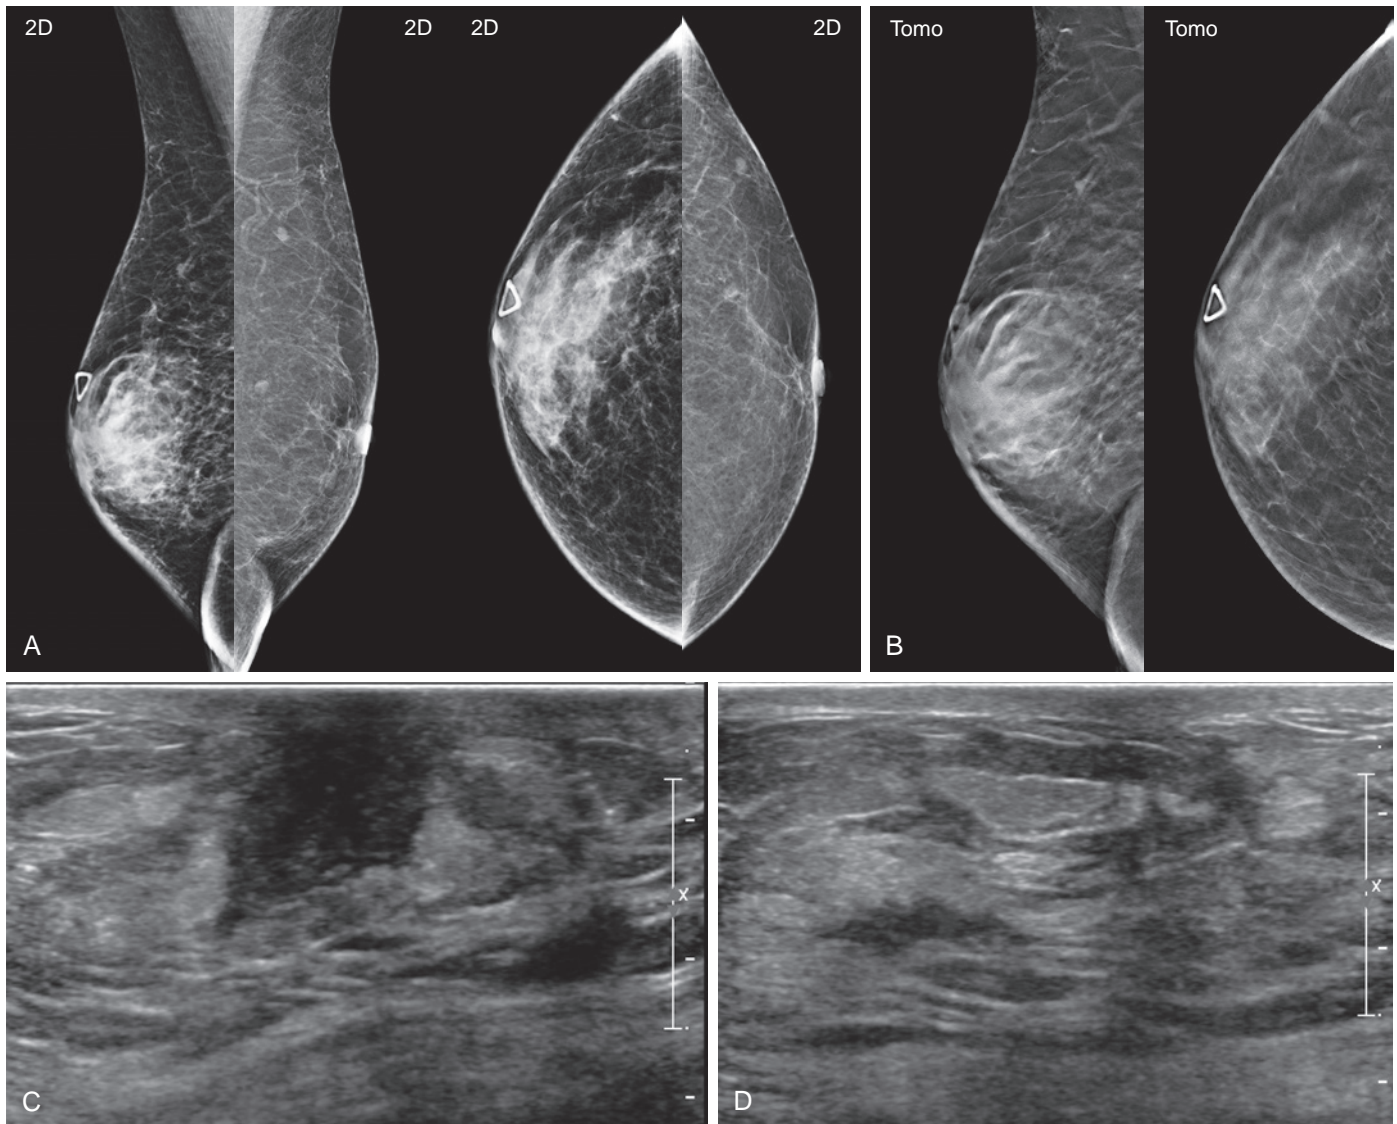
Right gynecomastia. A 66-year-old man presents with right breast swelling and tenderness. (A) There is marked gynecomastia of the right breast, with associated skin and trabecular thickening. (B) Tomosynthesis slice images in the mediolateral oblique and craniocaudal projections show dense tissue in a dendritic pattern. (C and D) Ultrasound shows a hypoechoic area in the subareolar region (C) consistent with focal glandular proliferation and mixed glandular tissue in the upper right outer quadrant (D).
